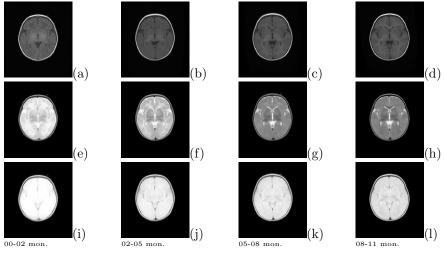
Axonal myelination during infant brain development affecting MRI signal. (a)-(d) T1-, (e)-(h) T2- and (i-l) proton density-weighted templates
